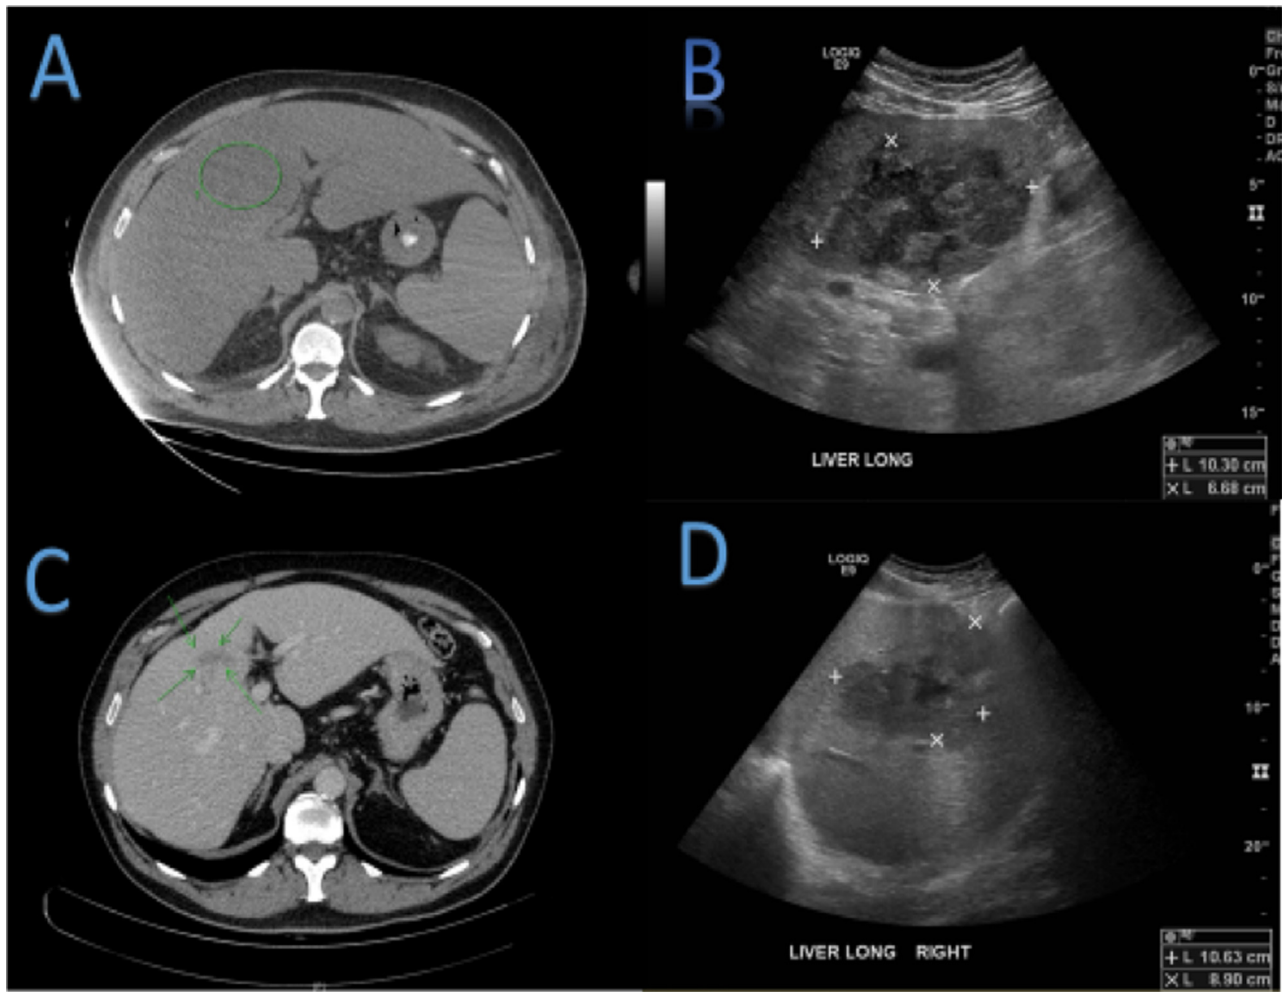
(A) CT of the abdomen without contrast shows (green oval) ill-defined areas of heterogeneous predominantly low attenuation throughout the medial segment of the left hepatic lobe, to a lesser degree within the lateral segment of the left hepatic lobe. Findings raise concern for a hepatic abscess. (B) Right upper ultrasound showing (white x's) complex mass with in the medial left lobe. The mass shows a heterogeneously hypoechoic echotexture and measures approximately $10.3 \times 9.3 \times 6.7$ cm. (C) CT scan of liver after drainage shows (green arrows) decreased sized/conspicuity of irregular areas of decreased enhancement in the liver, primarily involving the left hepatic lobe, suggestive of sequelae of previous hepatic abscesses. (D) Right upper ultrasound after IR-guided drainage shows (white x's) 10 cm area of heterogeneous echotexture secondary to residual abscess.
